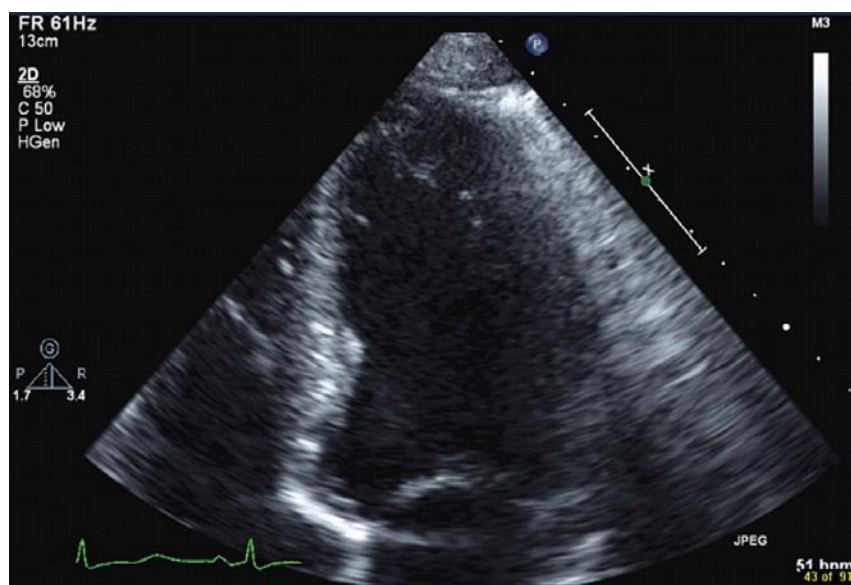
Postoperative transthoracic echocardiogram demonstrated only minimally remaining mural thrombus.
